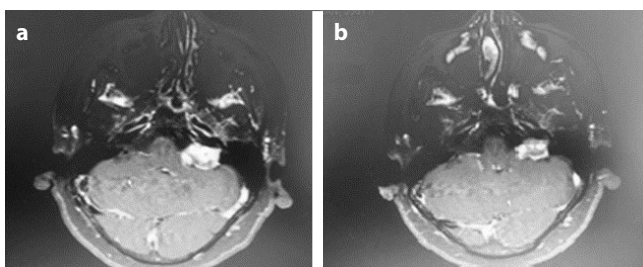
(a) Axial T1W MR images with preoperative contrast, (b) 18 months later axial T1W MR images with control contrast of a patient who underwent stereotaxic radiosurgery with CyberKnife. Tumor size appears to be reduced.
